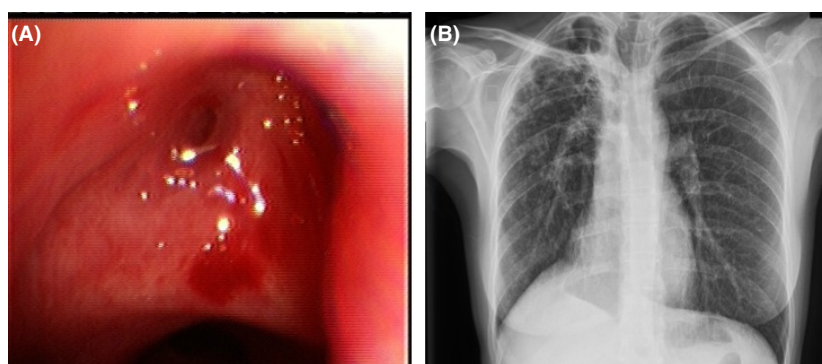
(A) The bronchoscopy showed a 90% stenosis of the segmental bronchi of the right upper lobe and signs of chronic inflammation. (B) The control chest X-ray showed a right lung loss of volume with ipsilateral mediastinal shift and significant improvement of the right upper lobe infiltrate and cavitations.
